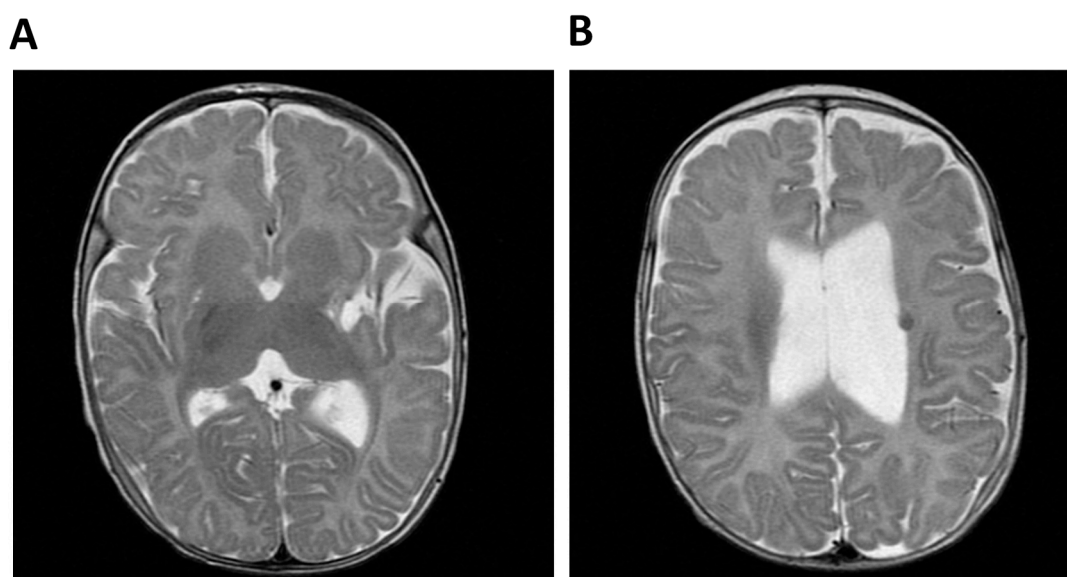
Cerebral MRI of Patient 1 (P1, index case). (A) Malacic area located at the lentiform nucleus and external left capsule and dilatation of the subarachnoid spaces of the insula and (B) Dilatation of the left lateral ventricle and T2-weighted hypointense lesion compatible with hemoglobin degradation.
